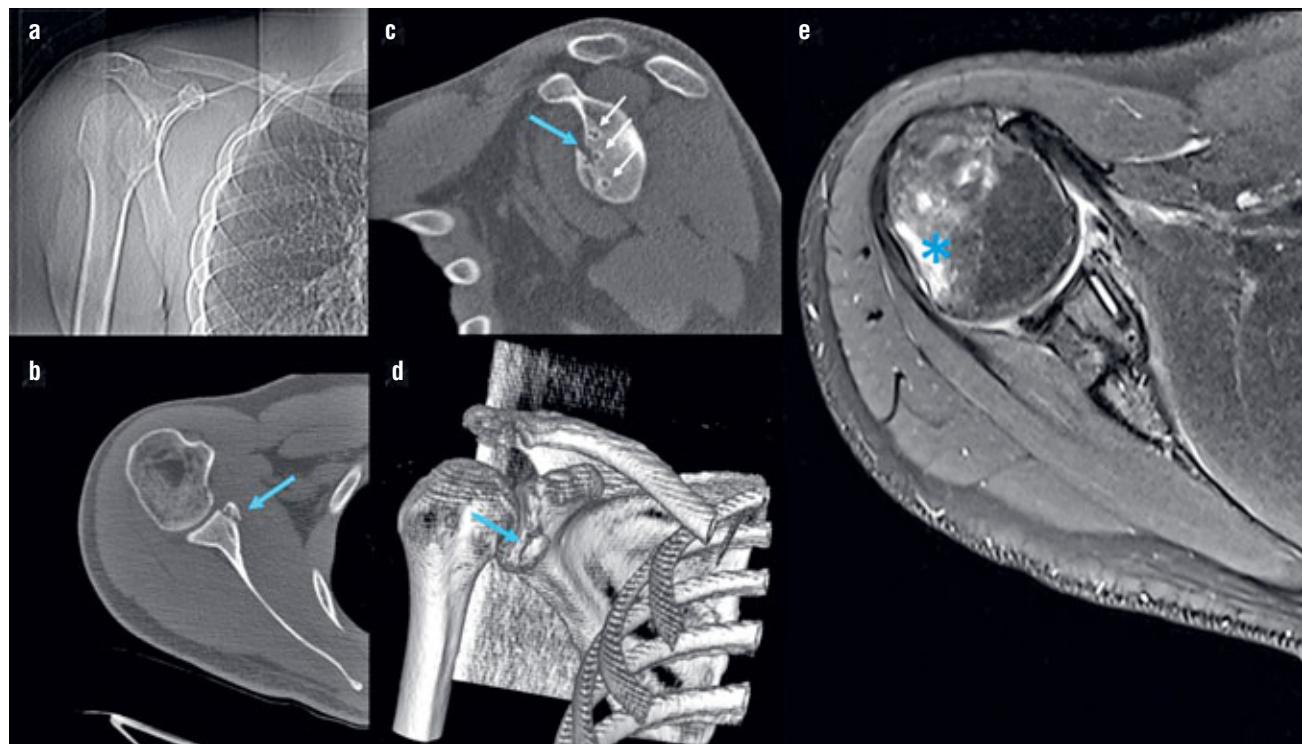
Plain X-ray (a) and CT scans (b, c, d) showing the anterior glenoid rim fracture (blue arrows) through previous anchor sites; MRI of the Hill-Sachs lesion (asterisk) (e). Note the osteolysis with clear sclerotic lines around anchor sites (white arrows).
